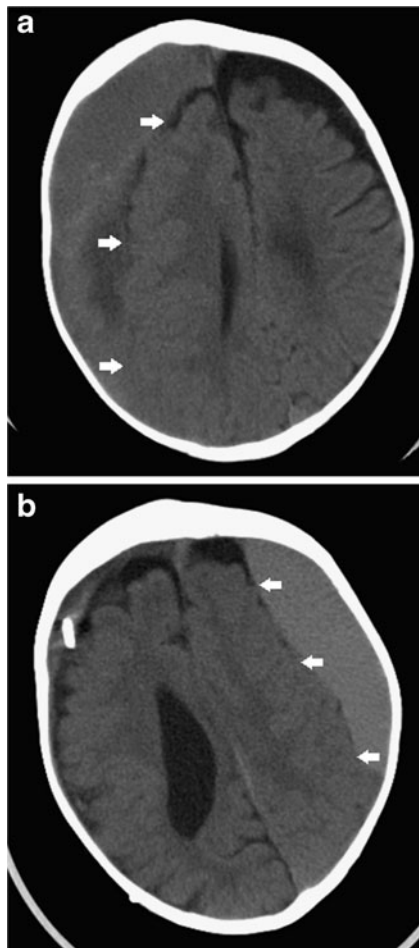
a CT scan showing the initial right isodense chronic subdural haematoma, delimited by *white arrows*. b CT scan showing the contralateral subdural haematoma, delimited by *white arrows*. Note the thickness of the frontal bone
